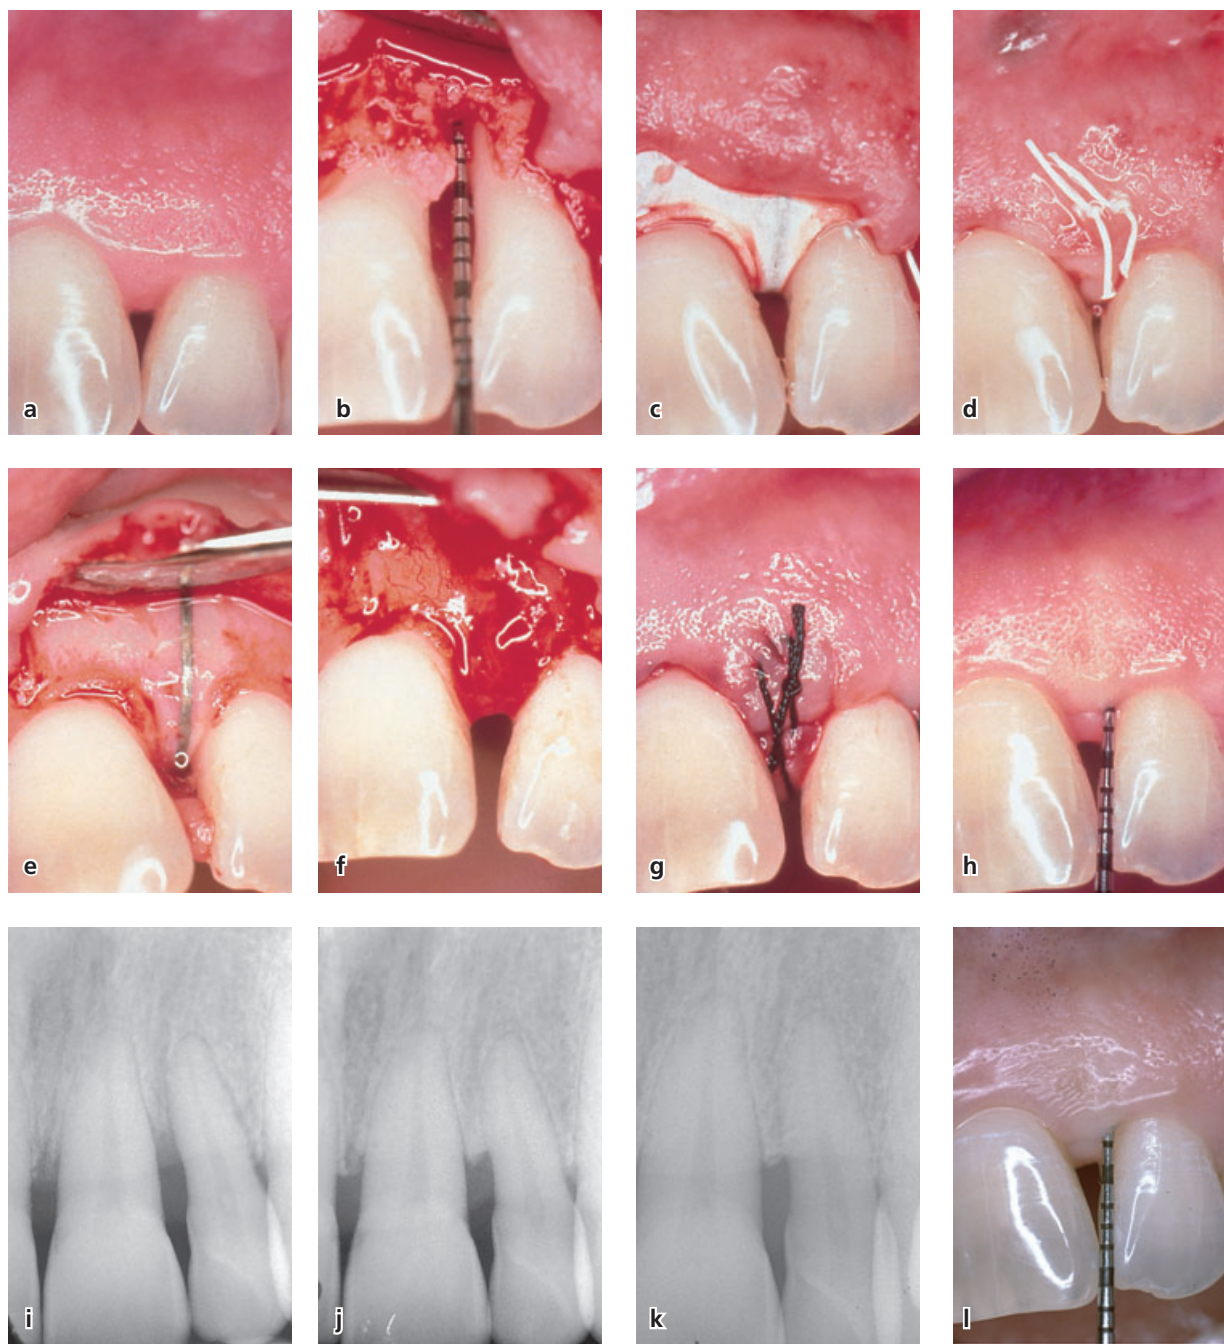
(a,b) Left maxillary lateral incisor with a deep interproximal intrabony defect on the mesial surface. (c) Flaps are raised according to the modified papilla preservation technique, and a titanium-reinforced barrier membrane is placed over the defect. (d) By coronal displacement of the flap and preservation of the interdental papilla, the membrane is completely covered. (e,f) After 6 weeks of uneventful post-operative healing the membrane was removed, (g) and the newly formed tissue was completely covered. (h) At 1 year, residual probing pocket depth was 2 mm and no buccal or interdental recession had occurred. (i) The baseline radiograph shows radiolucency approaching the apex of the tooth, but after 1 year the intrabony defect is resolved and some supracrestal bone apposition seems to have occurred (j). The radiograph taken at 6 years confirms the supracrestal bone regeneration (k) and the clinical image shows the integrity of the interdental papilla with optimal preservation of the esthetic appearance (l).
